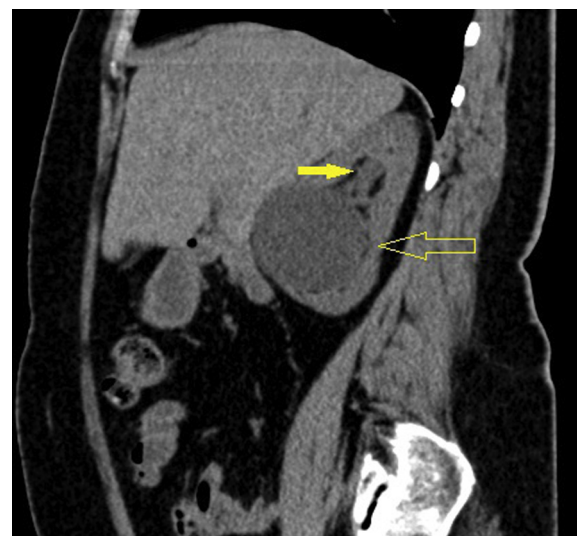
Thirty-four year old female patient with left flank pain. CT stone protocol in sagittal oblique plane through the left kidney shows a parapelvic cyst causing mild dilatation of the upper calyx with no stones. Cyst aspiration and sclerotherapy relieved the pain.
